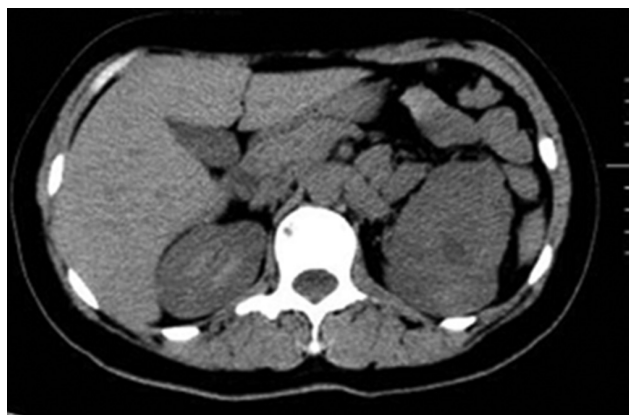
Computed tomography (CT) plain scan of the subject's mid-abdomen. The irregular soft tissue masses can be seen in the left lower pole of the kidney, with a size of 6.9 cm × 6.1 cm × 5.3 cm. These irregular masses are adjacent to the regions of destroyed renal parenchyma, having unclear boundary, uneven density, and an average CT value of 41 Hu.
